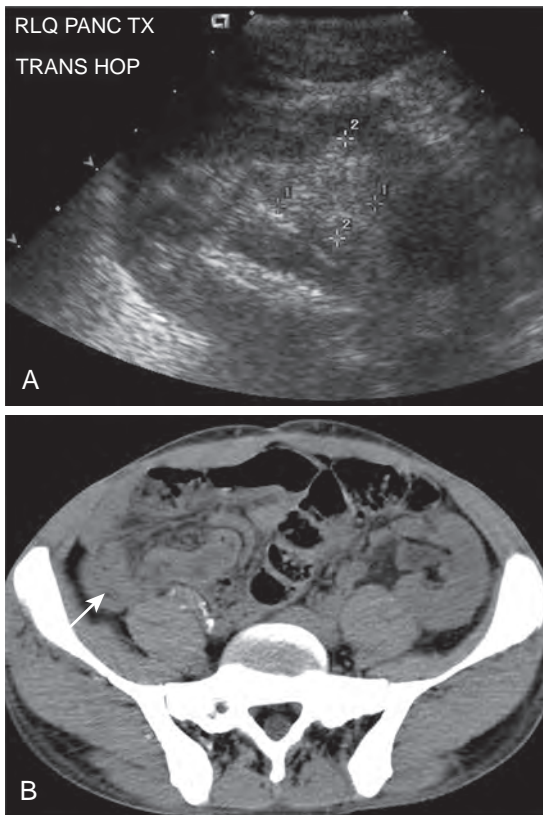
Chronic rejection in a 40-year-old man, 10 years after PAK transplantation. A. Transverse gray-scale US shows an atrophic echogenic pancreatic head (calipers) difficult to distinguish from mesenteric fat. B. Unenhanced CT image obtained before a CT-guided biopsy. Because the pancreas transplant (arrow) was small and difficult to separate from bowel, a biopsy could not be performed. C. Contrast-enhanced MRA showed a patent graft artery (not shown) and enhancing parenchyma (arrow) in the right lower quadrant. Note the enhancing left lower quadrant renal transplant. (From Vandermeer F, Manning MA, Frazier A, et al: *Imaging of whole-organ pancreas transplants*. *RadioGraphics* 32:411–435, 2012.)
